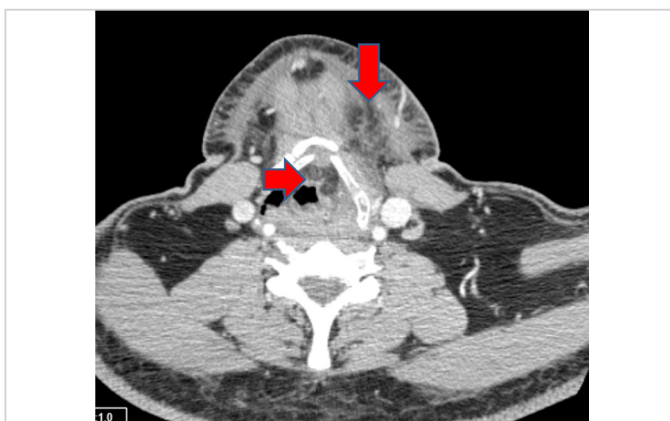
Neck CT, axial section showing abscess foci extending to the larynx (arrows)
